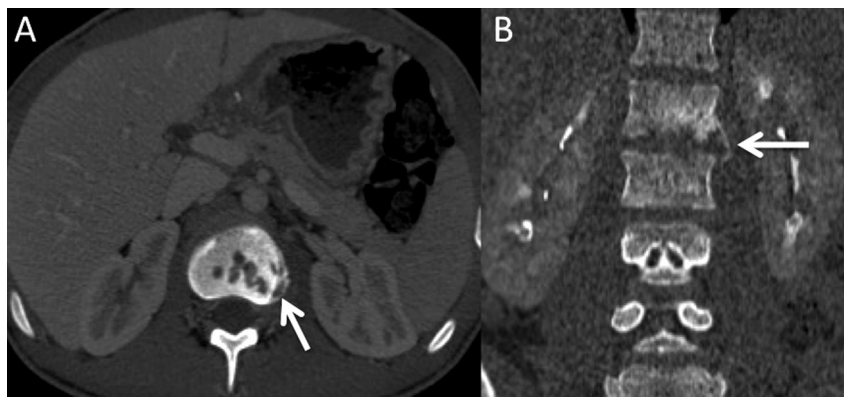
Multislice computed tomography (MSCT) examination, 11 weeks after the assault. (A) Axial view: irregular osteolytic cavities in superior L2 endplate (arrow). (B) Frontal multi-planar reconstruction (MPR): destruction of inferior L1 and superior L2 endplates (arrow).
